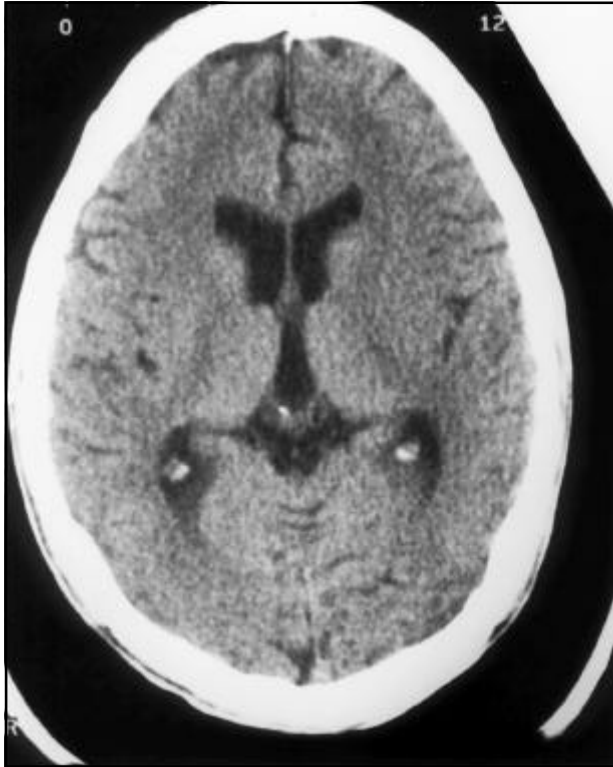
Head CT scan pre thrombolysis without intra-cranial hemorrhage.
